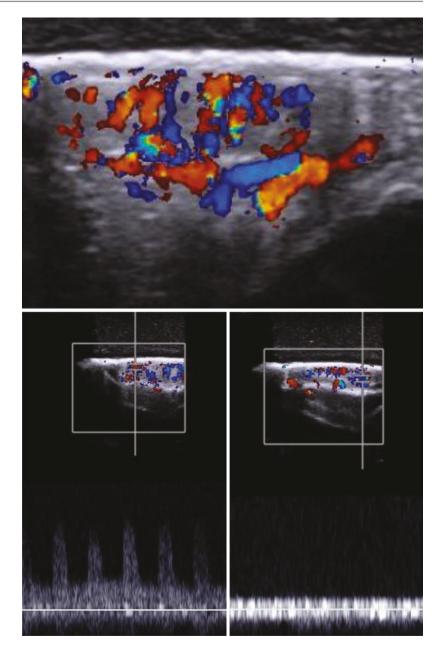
Doppler study shows intralesional hypervascularity with both arterial and venous flow, compatible with infantile hemangioma
